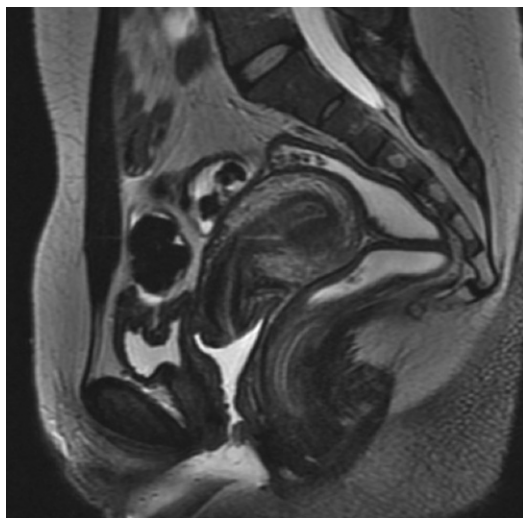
T2-weighted image. Sagittal plane. Vaginal fornix distended by gel and rectum distended by saline solution.
